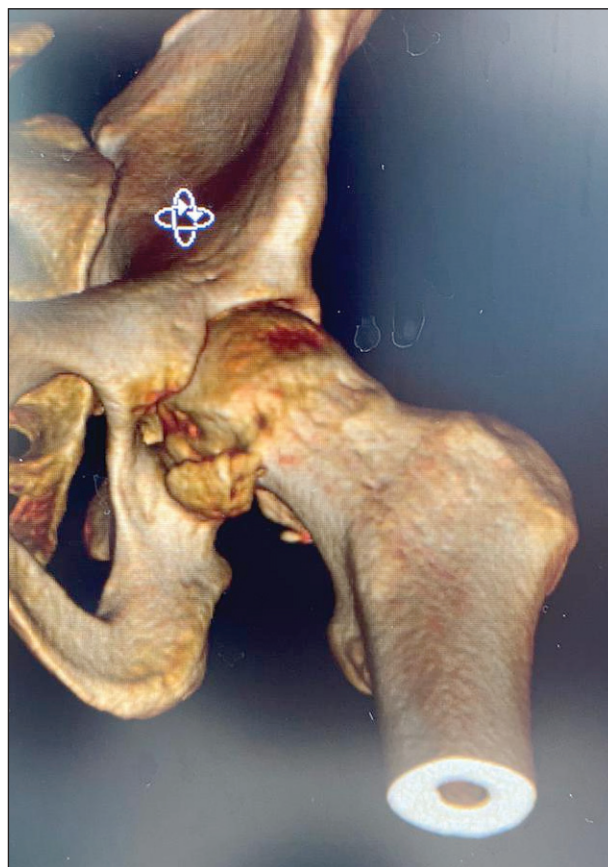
CT-scan slice showing a Pipkin type I fracture after femoral head reduction
